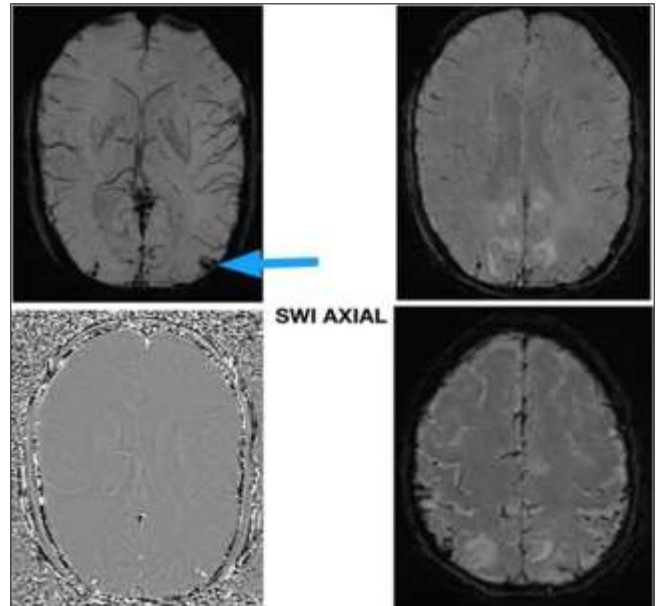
T2/FLAIR hyper intensity with blooming on SWI in subarachnoid space in bilateral parieto occipital sulci - S/O Acute subarachnoid haemorrhage
